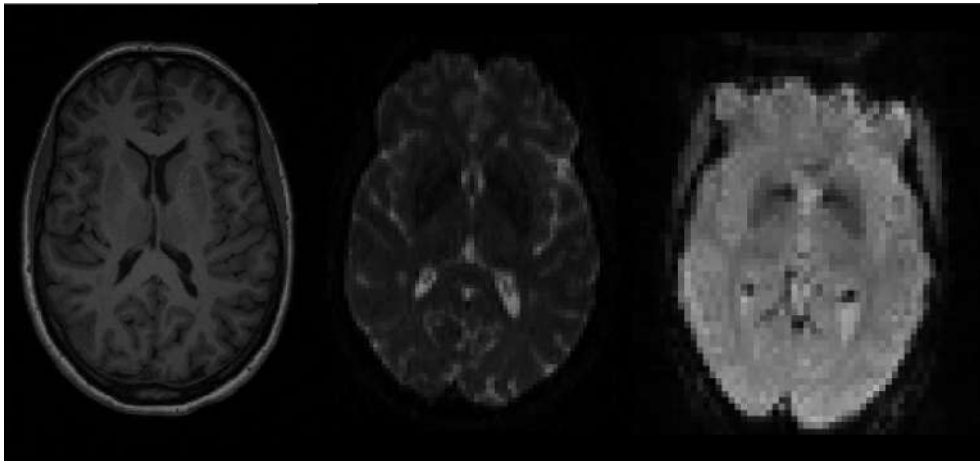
Examples of the three most commonly used MRI modalities. From left to right: structural T1-weighted imaging, diffusion weighted imaging and functional imaging.
